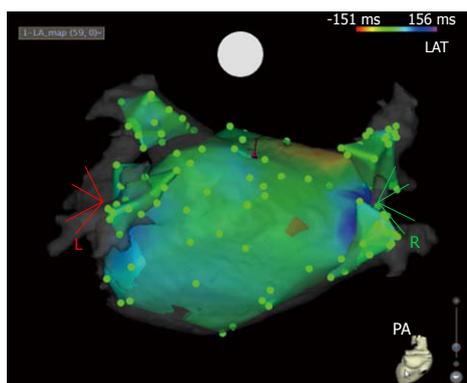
Postero-anterior view of the electroanatomic map shown in Figure 2 and of the three-dimensional rendering of the computed tomography scan, both in a postero-anterior view. A couple of points (small red flags on the electroanatomic mapping and computed tomography) have been identified on the left atrial roof. These two landmarks will be used to initially guide the superimposition of the two surfaces. CT: Computed tomography.
